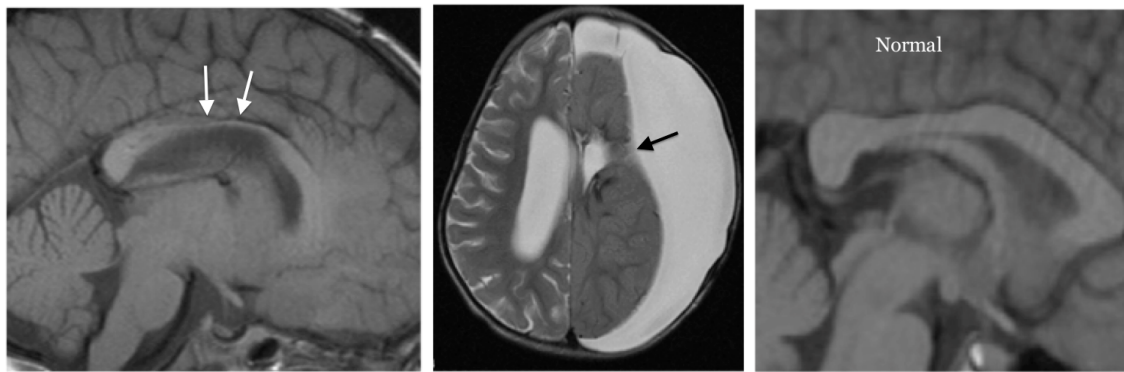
Sagittal T1 MRI image of central corpus callosum thinning (white arrows) corresponding to unilateral brain loss after excision of a left-sided tumour (black arrow) on T2, with a comparison sagittal T1 weighted image showing thickness of the corpus callosum in a normal child (Normal)
